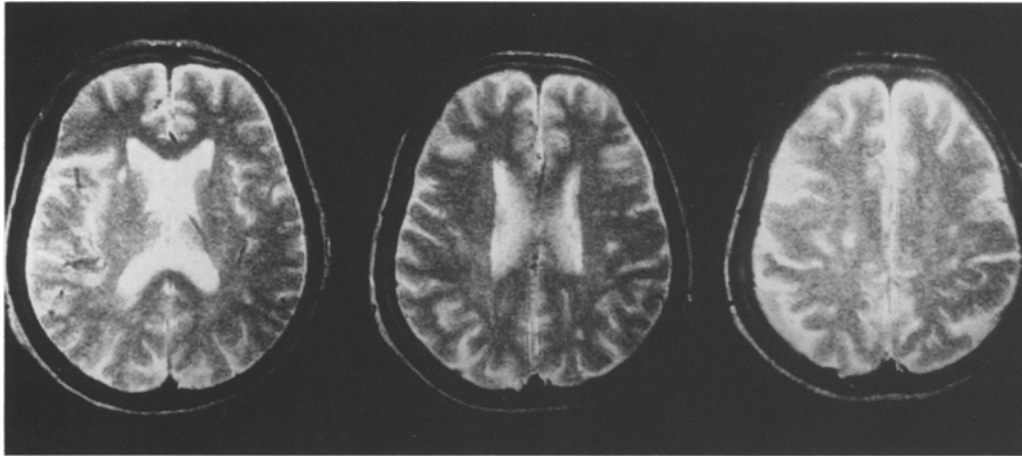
MRI of case 2. High signal lesions in white matter, predominantly in periventricular area (TR = 2000 ms, TE = 80 ms)
